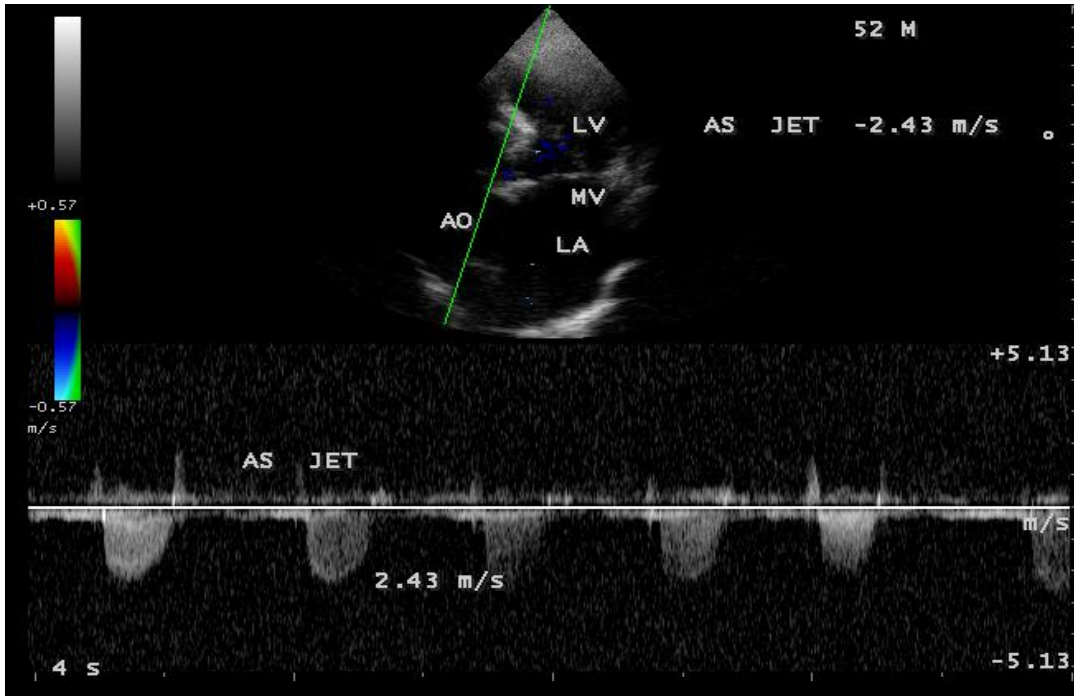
CW (continuous wave) Doppler showing the aortic stenosis jet in a 52-year-old male.
